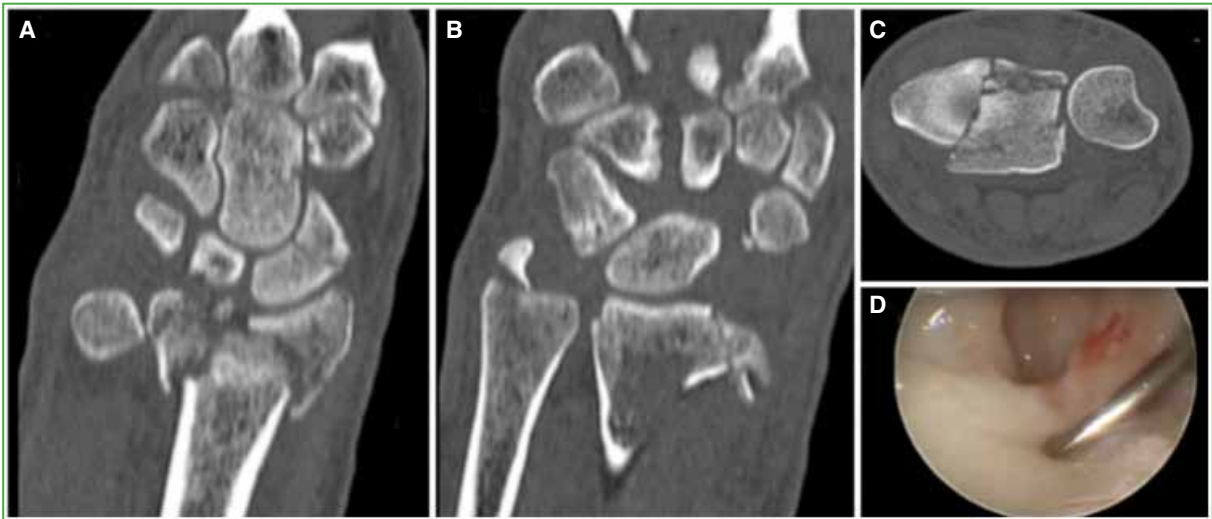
TFCC injury. A. Computed tomography of the wrist, coronal section. Radial lunette facet fracture and scaphoid fracture. B. Wrist computed tomography, coronal section. Fracture of ulnar styloid. C. Distal radioulnar subluxation and radial lunette facet fracture. D. Arthroscopic view through portal 3-4-R. Injury at the level of the triangular fibrocartilage in its dorsal portion.
